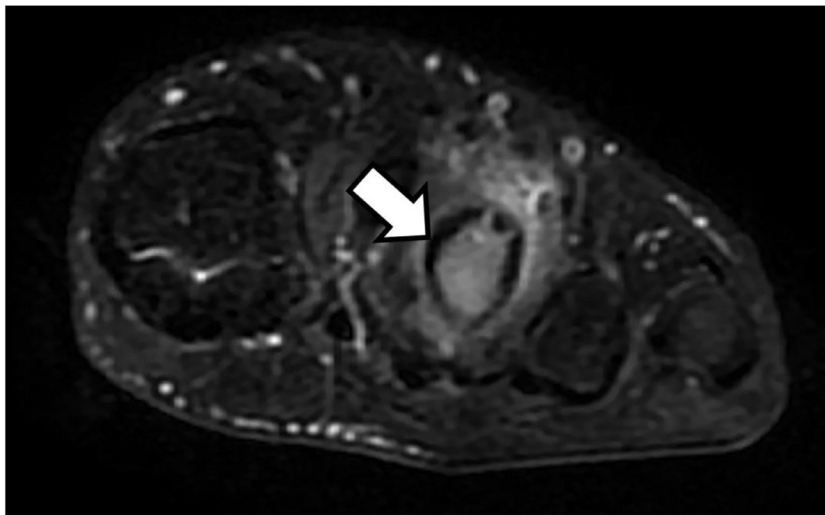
Coronal fat-saturated proton density (PD) sequence of MRI scan of the left foot. Perilesional edema is better displayed as diffuse hyperintensity surrounding tumor site (arrow).
